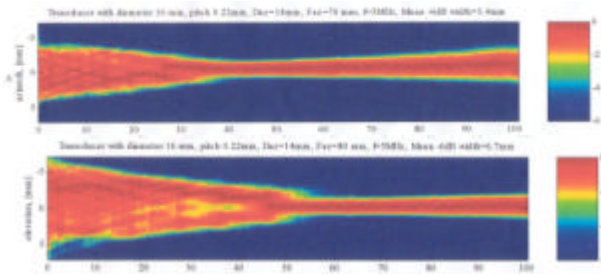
Transesophageal phased-array responses.
